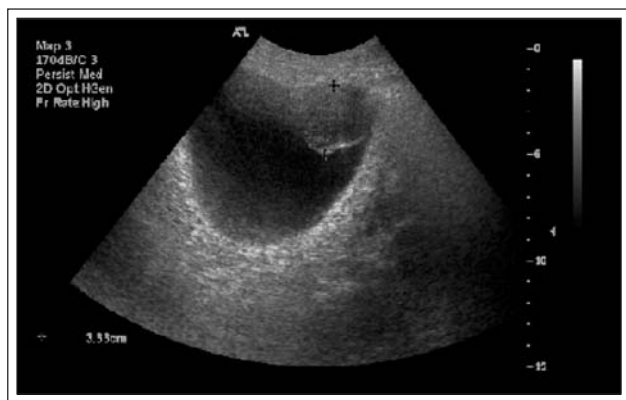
Case two. Preoperative ultrasound showing the bladder mass.
